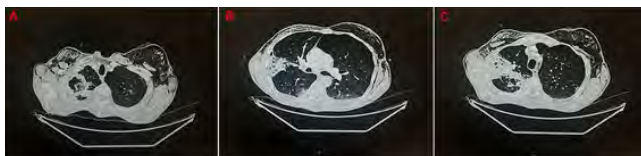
Chest CT scan. A. Cavitated lesion with a maximum axis of 55mm, with thickened walls and heterogeneous content, related to probable necrotizing pneumonia. B) Focal areas of alveolar hemorrhage. C) Pneumothorax and subcutaneous emphysema.
